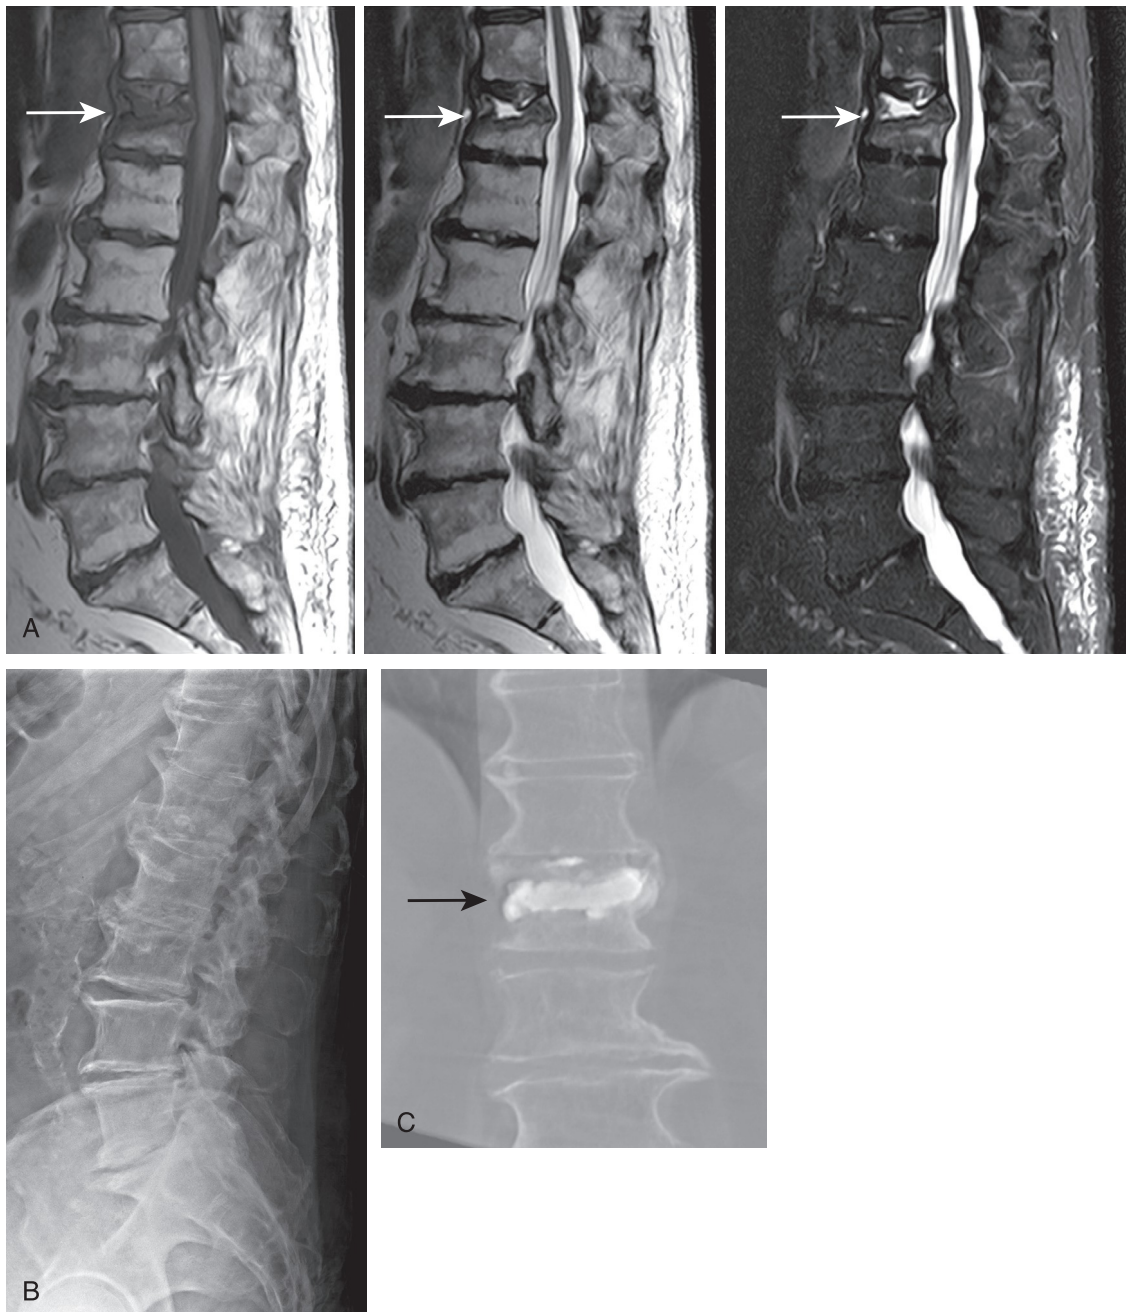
Kummel disease, 86-year-old male with reported fall from standing position 8 months prior, now with positional pain aggravated by sitting, and noted to walk in a stooped position. (A) Sagittal T1, T2, and T2 fat-saturated sequences demonstrate fluid-filled cavity within the upper T12 vertebral body with mild vertebral collapse and posterior cortical buckling (*arrows*). Thick sclerotic changes are also seen along the margin of the cavity without marrow edema. (B) Normal T12 vertebra on lateral lumbar radiograph at time of initial injury 8 months prior. (C) Coronal DynaCT reconstruction demonstrates filling of the osteonecrotic cavity after vertebroplasty (*arrow*).
